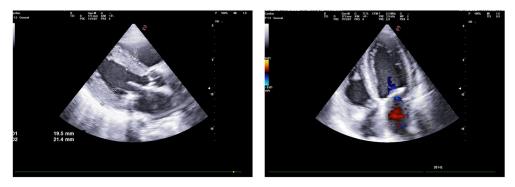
c.5. Concentric left ventricle hypertrophy, normal intraventricular diameters, thick mitral valves and granular appearance of the myocardium in a case with restrictive cardiomyopathy due to amyloidosis (left: parasternal long axis view; right: apical 4-chambers view)
